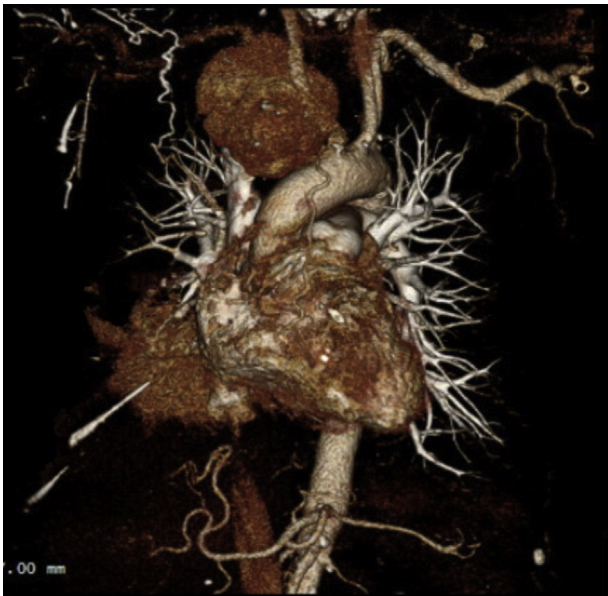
Reconstituted imaging using volume-rendered computed tomography angiogram of the chest revealing a large aneurysm that measured at $7.1 \times 5.7 \times 6.1$ cm and beginning just distal to the right subclavian artery origin.
